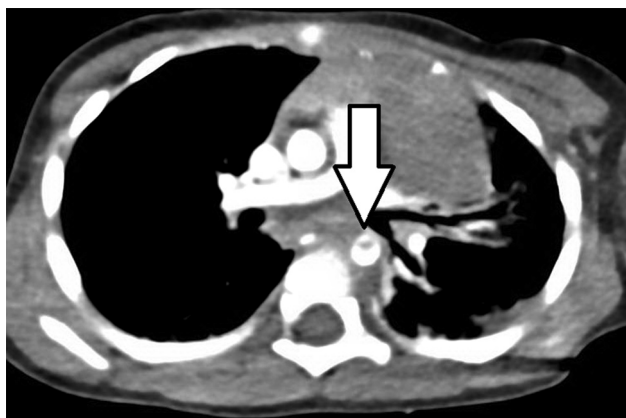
Screening axial CT with intravenous contrast. The arrow marks the location of aortic injury.
